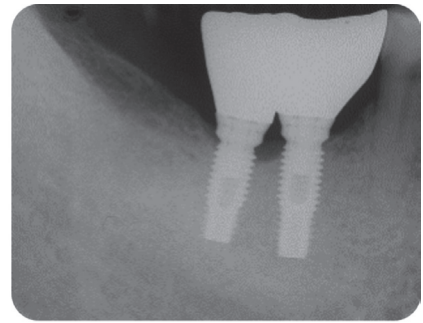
Periapical radiograph of the five-year follow up demonstrating the complete disappearance of periapical lesion.
